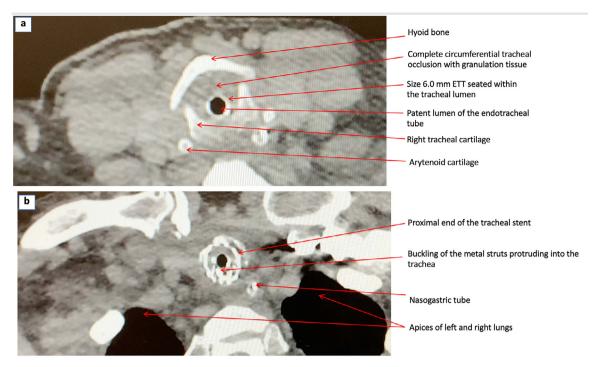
A computed tomography axial view of the neck demonstrating granulation tissue formation in the (A) trachea and (B) stent buckling with in-stent stenosis. ETT, endotracheal tube.
